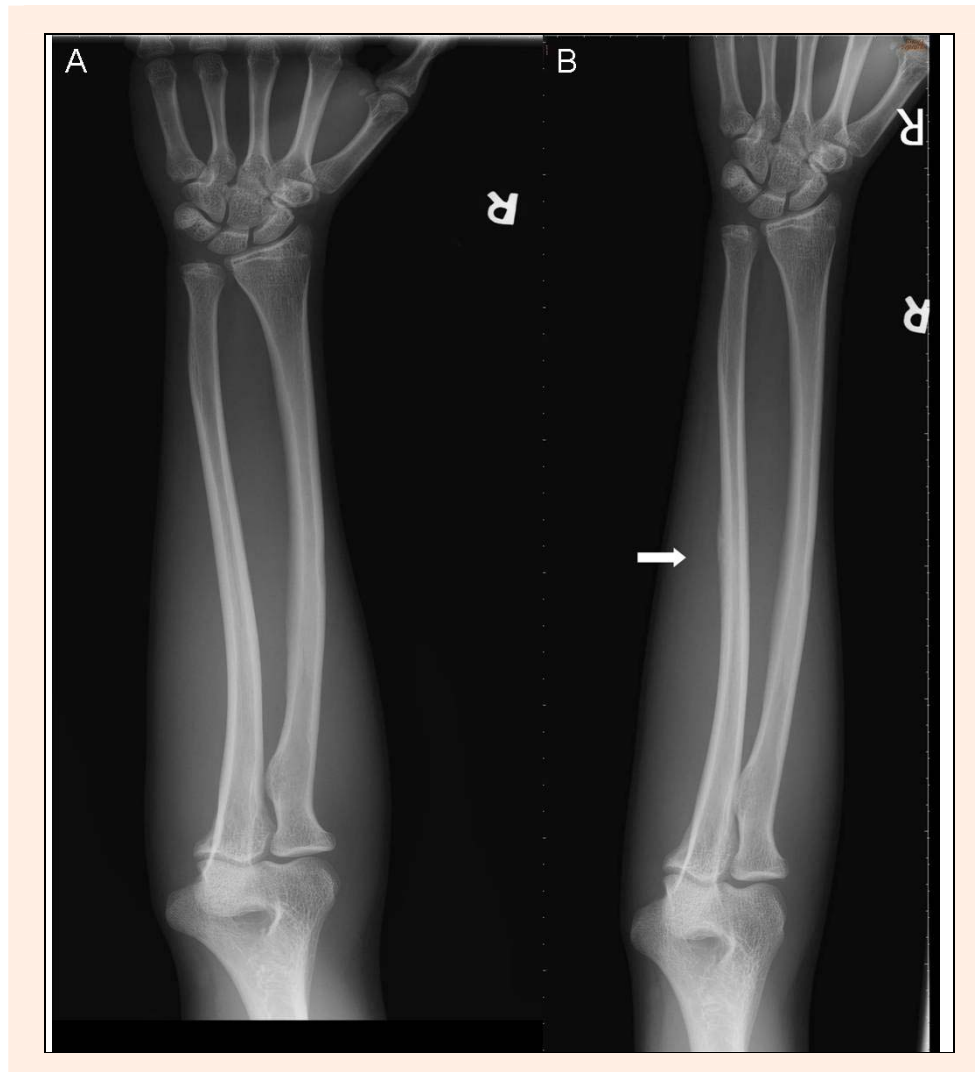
Radiographs of the ulnar shaft at presentation (A) and at three months (B). Note the solid callus formation (arrow) over the middle-one third of the ulna, confirming stress fracture of the shaft.
